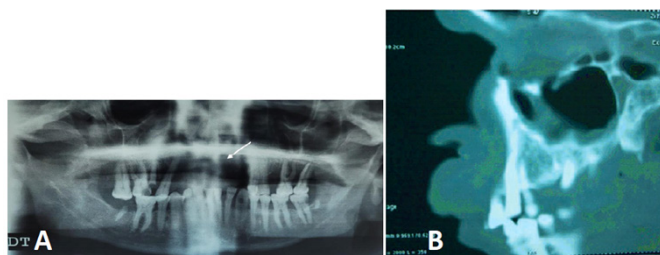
panoramic dental radiograph (A) and CT scan (B) showed bone erosion of the upper maxillary bone with a localized, hyperdense, malignant-looking tissue process.
